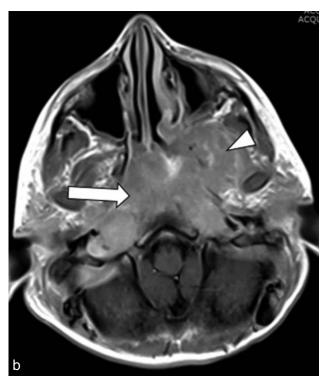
Axial T1-weighted image after IV gadolinium administration through the skull base showing enhancing soft tissue infiltrating the base of skull (arrow) and left infratemporal fossa (arrow head).
